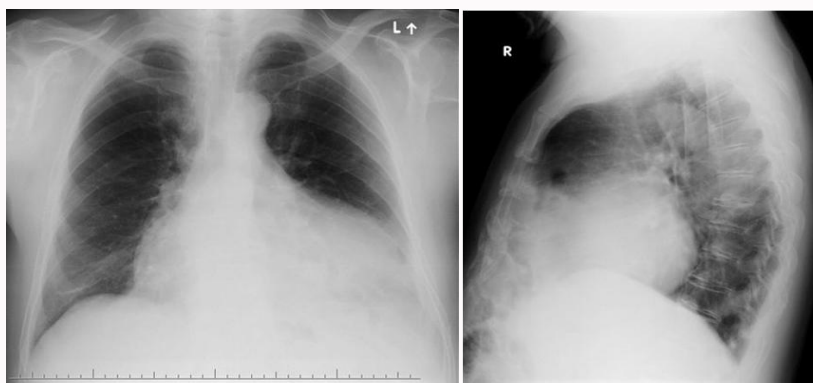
Preoperative chest X-ray. A) Antero-posterior; B) Lateral view.
